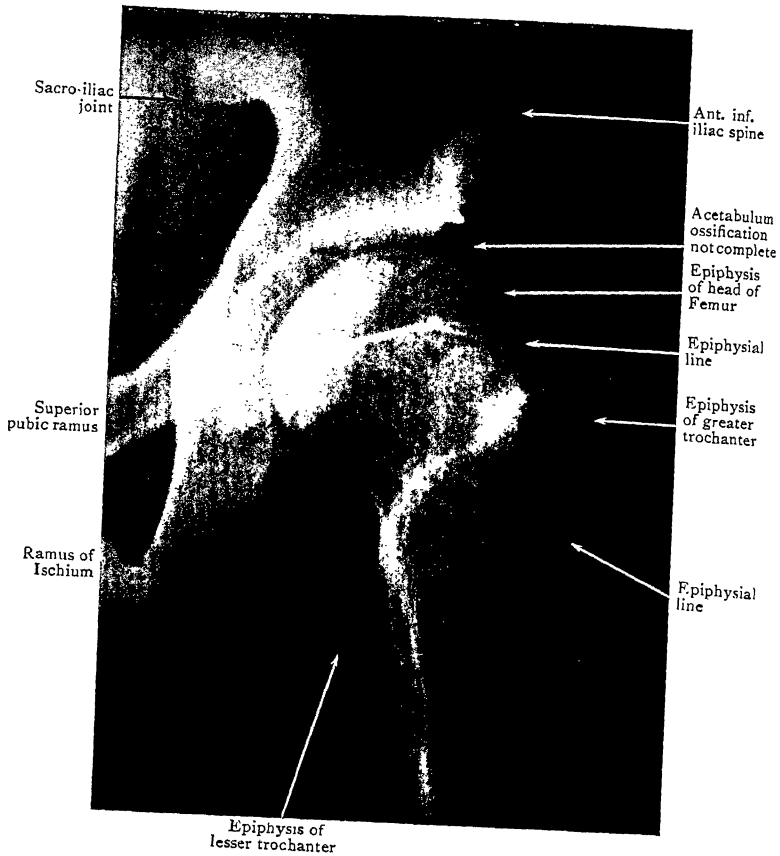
Radiograph of Hip of boy aged 14.
